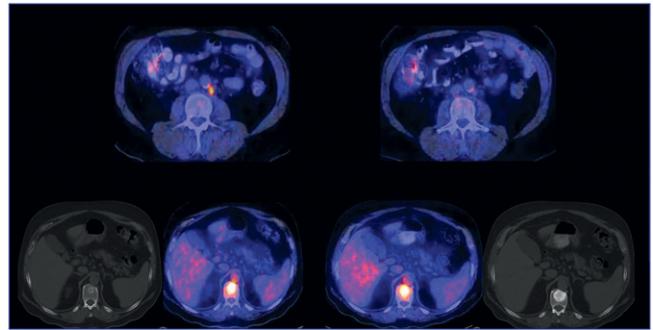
Treatment response assessment of metastatic prostate cancer with ^{18}F -FDG PET/CT. Treatment-related decline in bone metastasis metabolism on PET was associated with an increase in lesion density on CT.
